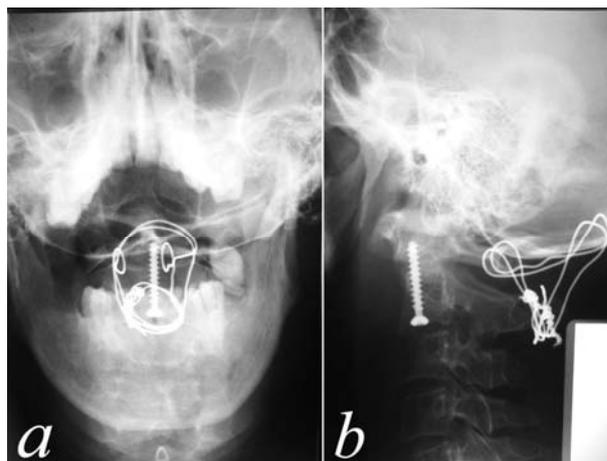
X-ray of type III dens fracture non-union managed with modified posterior occipitocervical fusion followed by direct odontoid screw fixation. a – front view; c – lateral view
